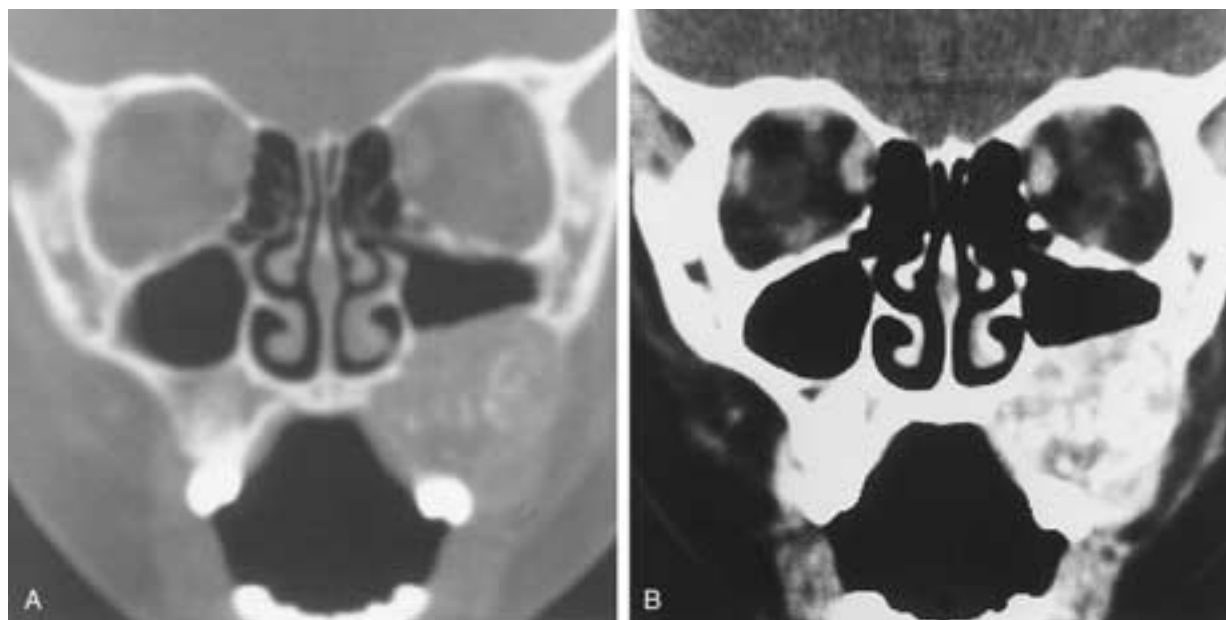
Giant cell granuloma of the left maxilla. A, Coronal CT (bone window setting) shows an expansile lesion in the left maxilla bulging into the left lower antrum and adjacent oral cavity. Note the calcific densities within the lesion. B, Coronal CT (soft-tissue window setting) demonstrates to better advantage the calcific and bony densities within the expansile lesion.
